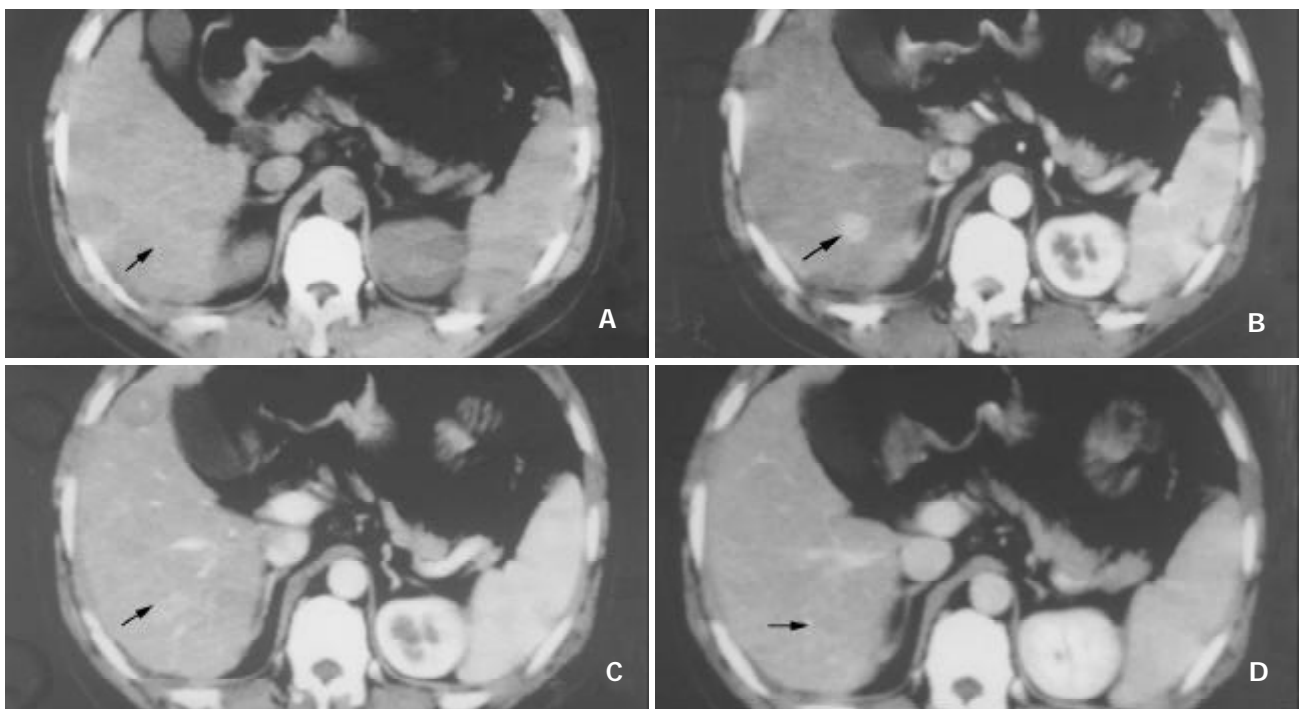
SHCC of 1.5 cm in diameter, A: Hypoattenuating lesion showed in precontrast image. B: CT scan obtained at the same level as in the early arterial phase, Tumor intensely enhanced. C: In the late arterial phase tumor becomes isodense (arrow). D: In the portal venous phase, the tumor turned to hypodense.
